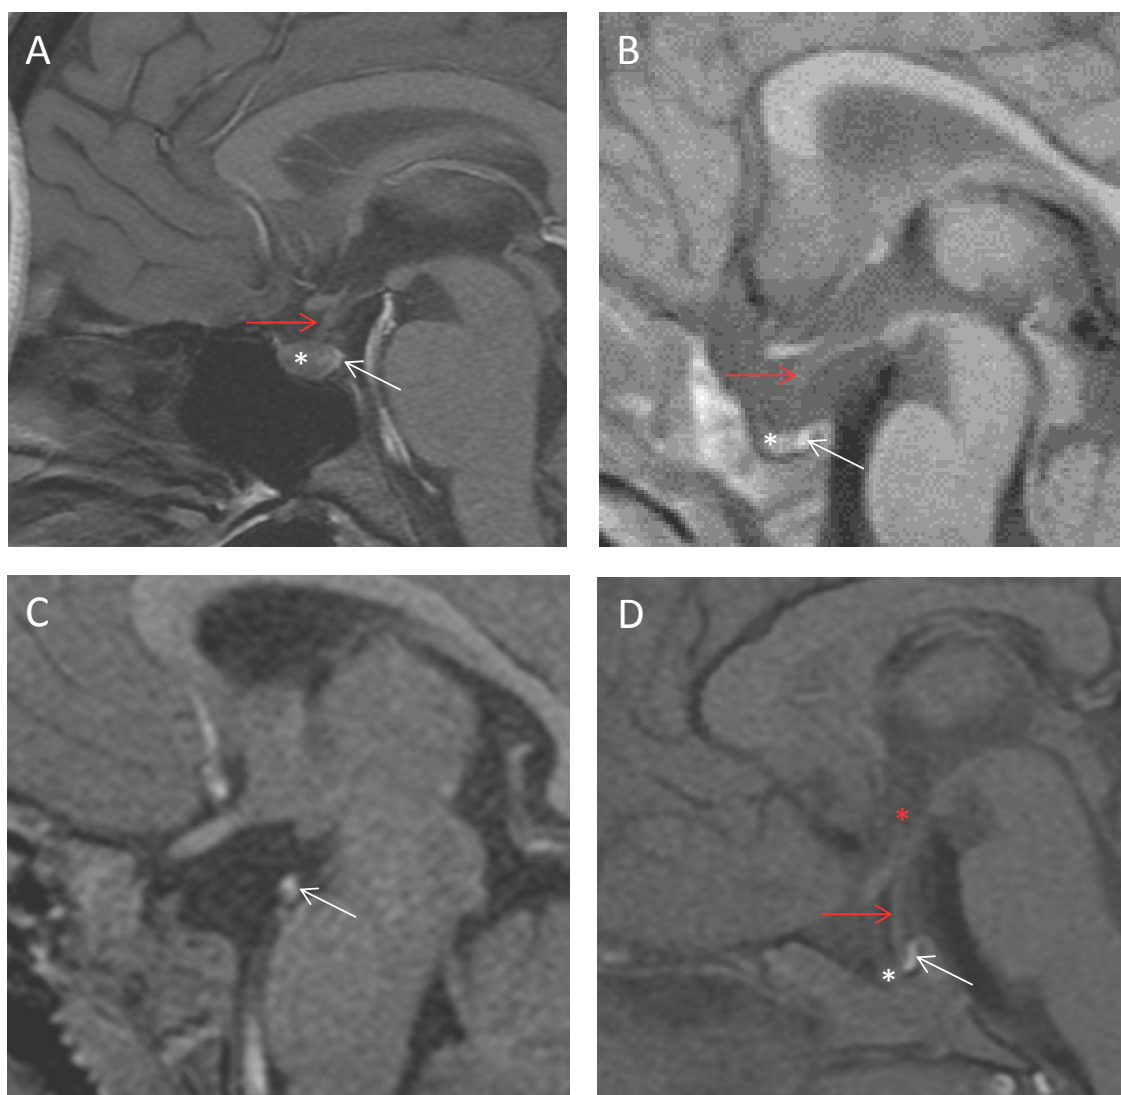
Magnetic resonance imaging (MRI) of the brain at the pituitary, stalk and hypothalamic area in representative patients of our CCH cohort. (A) Normal morphology, structure and size of pituitary and stalk. (B) Hypoplastic adenohypophysis, eutopic neurohypophysis and conserved pituitary stalk. (C) Hypoplastic adenohypophysis, neurohypophysis ectopia and absence of pituitary stalk (the TRIAD sign) (D) Adenohypophysis and hypothalamus hypoplasia with eutopic neurohypophysis and normal stalk. White and red arrows represent pituitary neurohypophysis and stalk, respectively. White and red asterisk represent pituitary adenohypophysis and hypothalamus, respectively.
